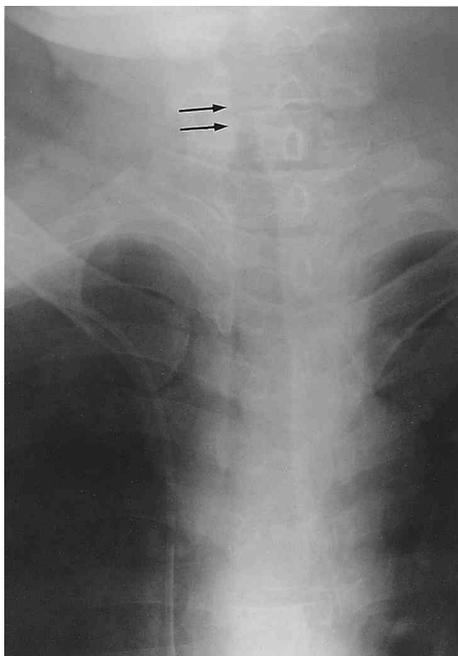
Major airway lesion by inhalation injury in a 49-year-old man. Chest radiograph taken ten hours after smoke inhalation shows irregular narrowing and fuzziness of the outline (arrows) of upper trachea.
